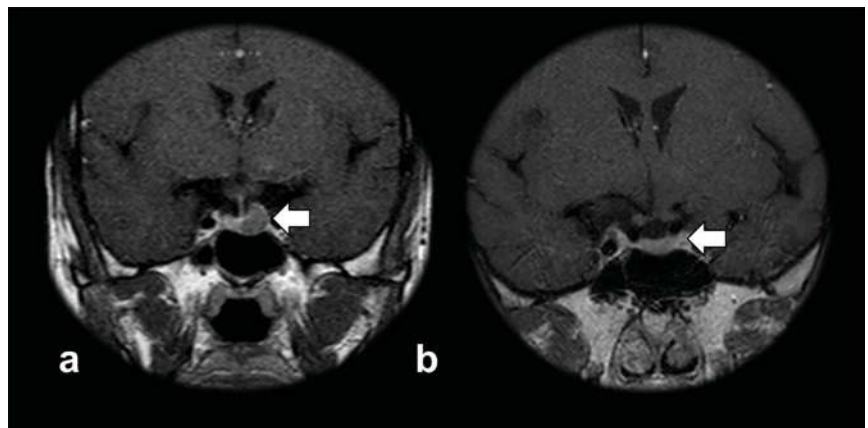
Pituitary MRI, coronal post-gadolinium T1-weighted sequence (a) demonstrate a rounded region of delayed enhancement in the left pituitary compared to the rest of the gland, compatible with adenoma. (b) Imaging follow-up showed a significant reduction of the lesion.
